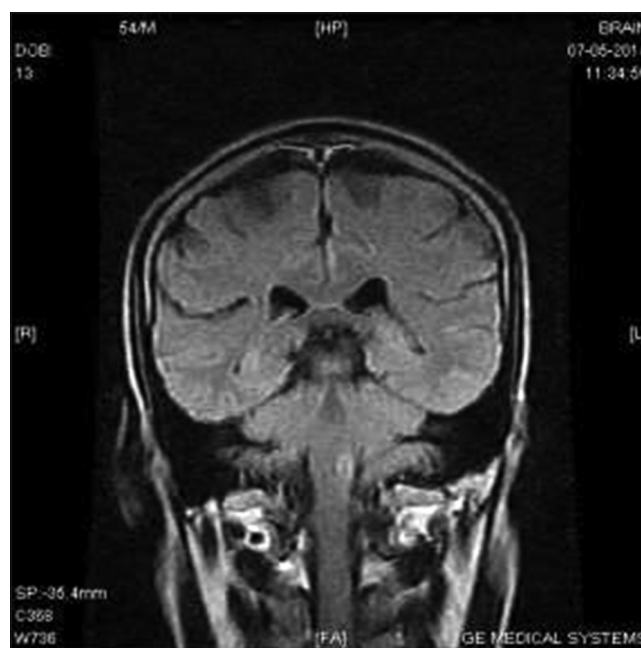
High intensity area in the left lateral and dorso-medial medulla in T2-weighted image
